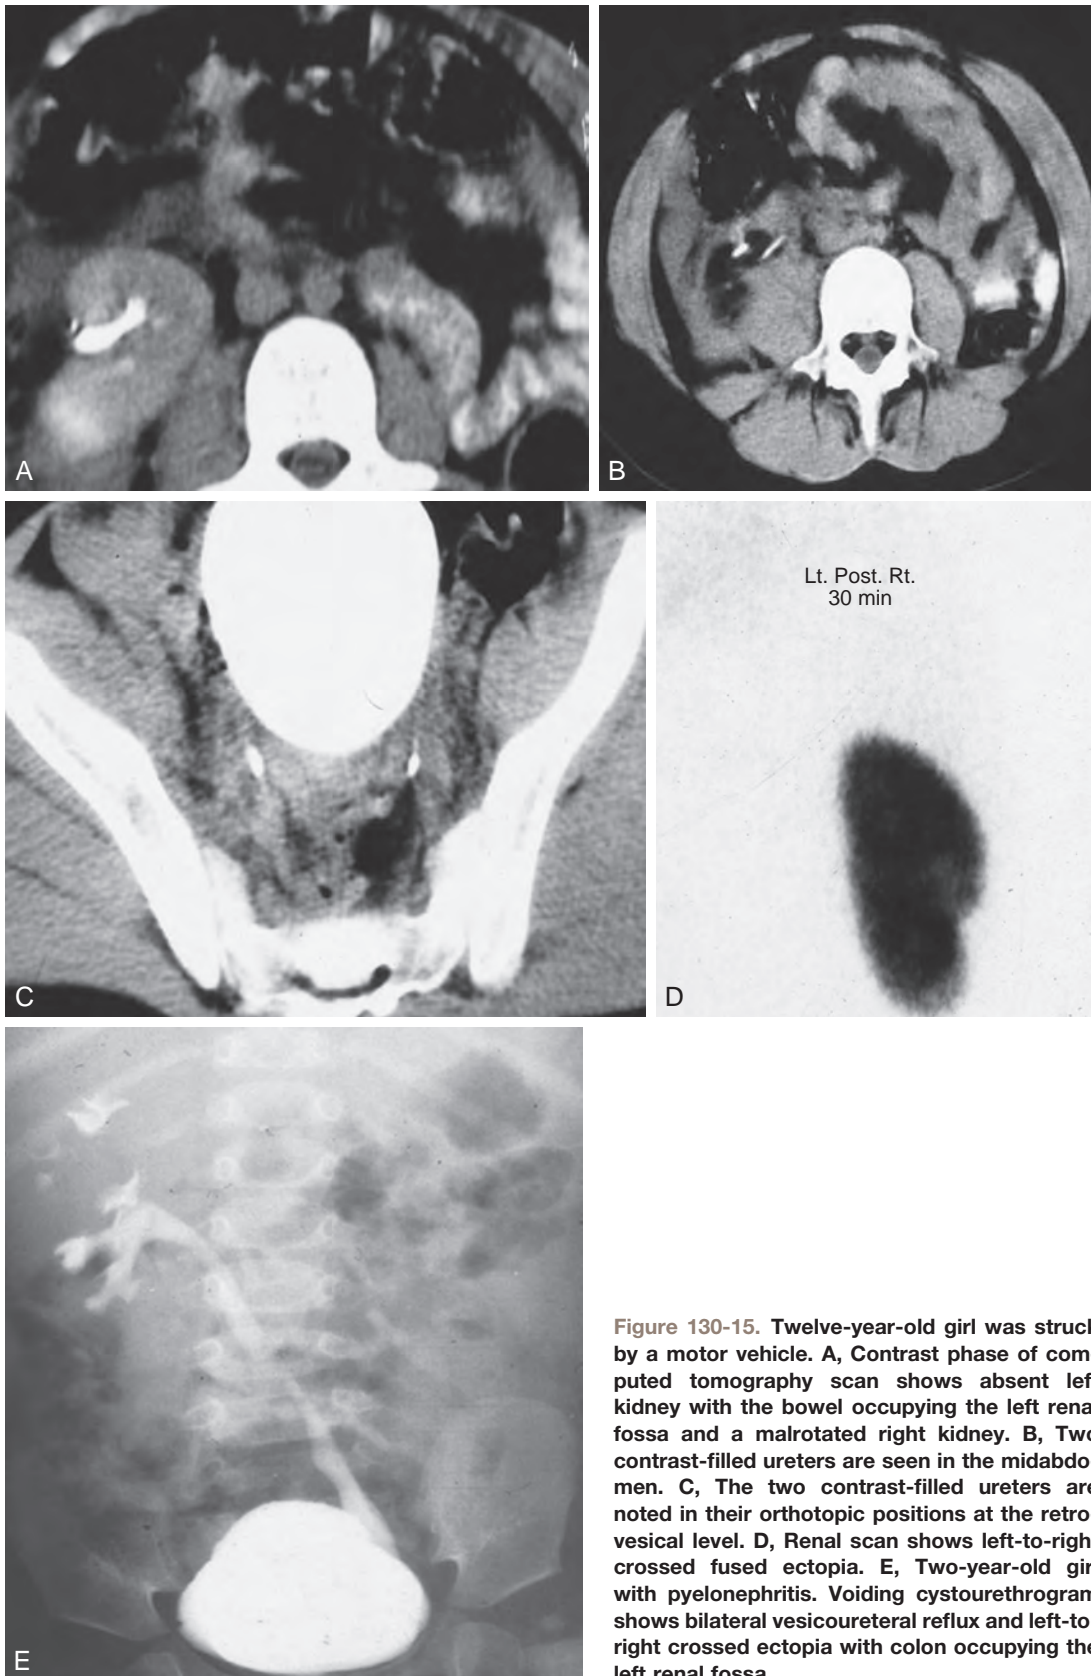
Twelve-year-old girl was struck by a motor vehicle. A, Contrast phase of computed tomography scan shows absent left kidney with the bowel occupying the left renal fossa and a malrotated right kidney. B, Two contrast-filled ureters are seen in the midabdomen. C, The two contrast-filled ureters are noted in their orthotopic positions at the retrovesical level. D, Renal scan shows left-to-right crossed fused ectopia. E, Two-year-old girl with pyelonephritis. Voiding cystourethrogram shows bilateral vesicoureteral reflux and left-to-right crossed ectopia with colon occupying the left renal fossa.
